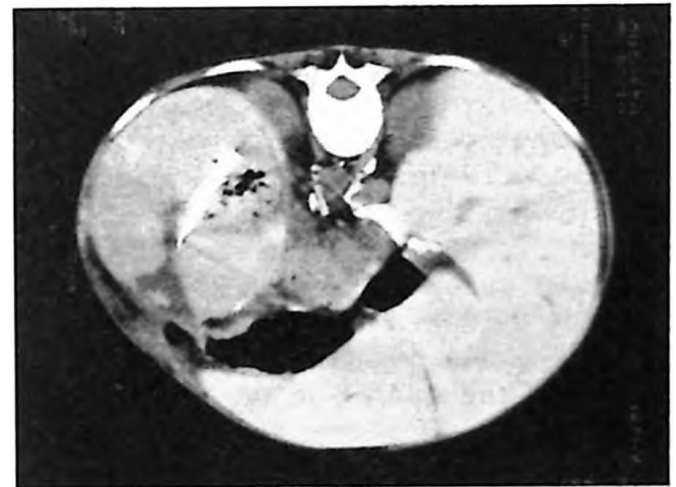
Abdominal computed tomography showing the normal and necrotic splenic parenchyma.
